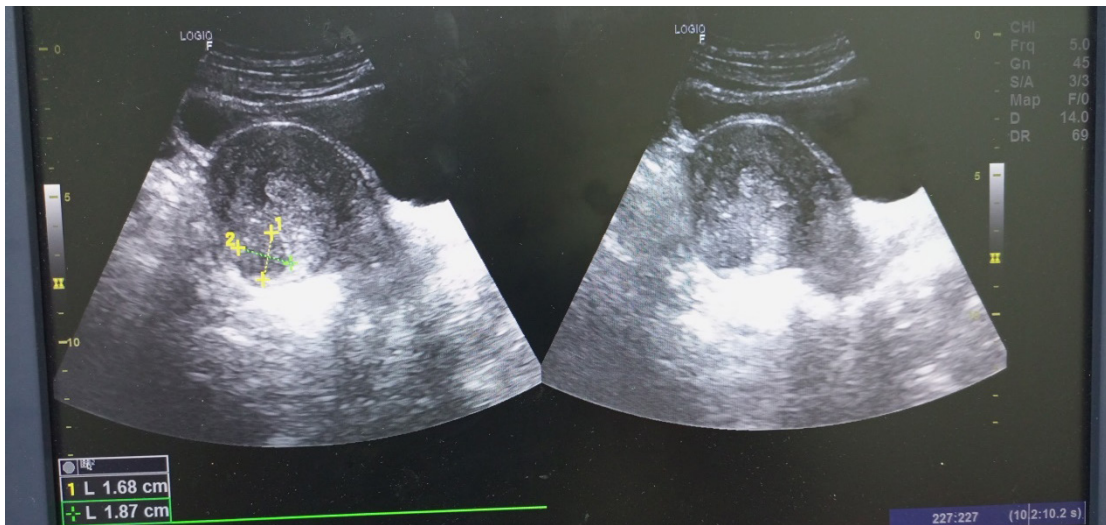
Static grey scale sonograms of a subserosal heterogeneous mass in the posterior aspect of the uterus.
